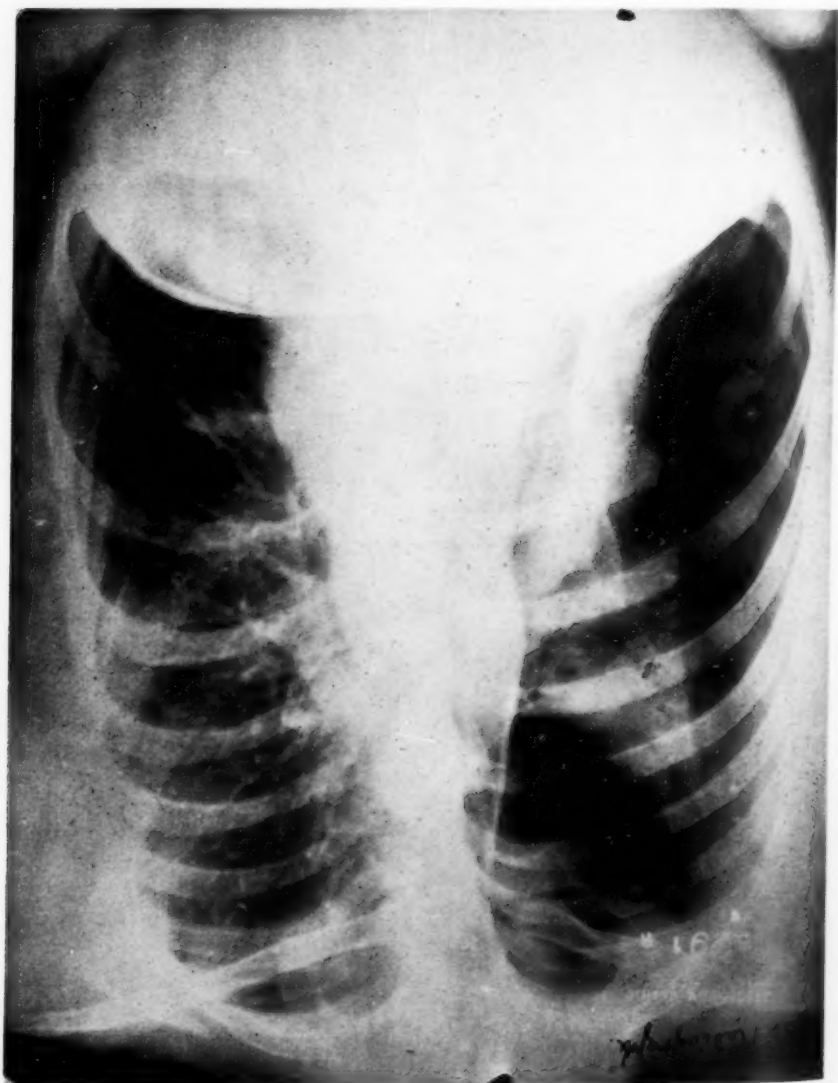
Radiograph of Case No. I at time of pneumothorax.
